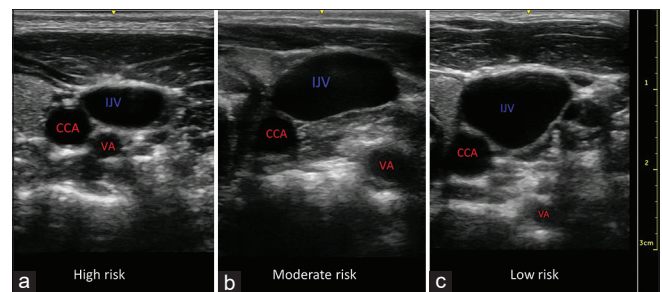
Transverse ultrasound images showing high-risk (a), moderate-risk (b) and low-risk (c) anatomical relation between VA, IJV and CCA. IJV: internal jugular vein, CCA: common carotid artery, VA: vertebral artery
